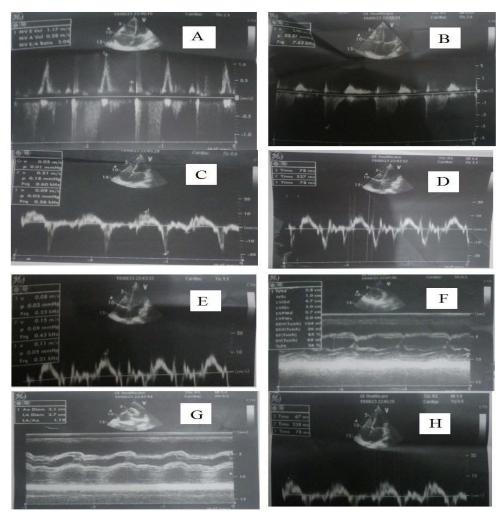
TDI Dimensions: A: By Pulsed doppler, MV E vel.=1.17m/s, MV E/A ratio  $\geq$  2. B: By Cont. doppler, TR jet vel.=2.9m/s, TR jet pressure=33 mmHg, PASP=43 mmHg. C: By TDI Lateral aspect show S`=0.09m/s, E`=0.21m/s, A`=0.05m/s. D: By TDI Septal aspect show IVRT =78ms, ET= 227ms, IVCT= 78ms.. E: By TDI Septal aspect show S`=0.11m/s, E`=0.15m/s, A`=0.08m/s. F: By M-Mode, Normal LV dimensions & systolic function.. G: By M-Mode, Normal LA & Aortic Root dimensions. H: By TDI Lateral aspect show IVRT =78ms, ET= 238ms, IVCT= 67ms
